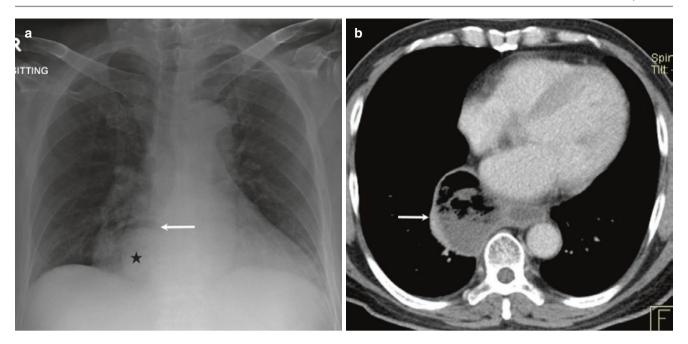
A 53-year-old woman with an epiphrenic diverticulum. (a) Frontal radiograph shows displacement of azygo-esophageal line (arrows). (b) Axial CT image demonstrates the epiphrenic diverticulum (arrow)
